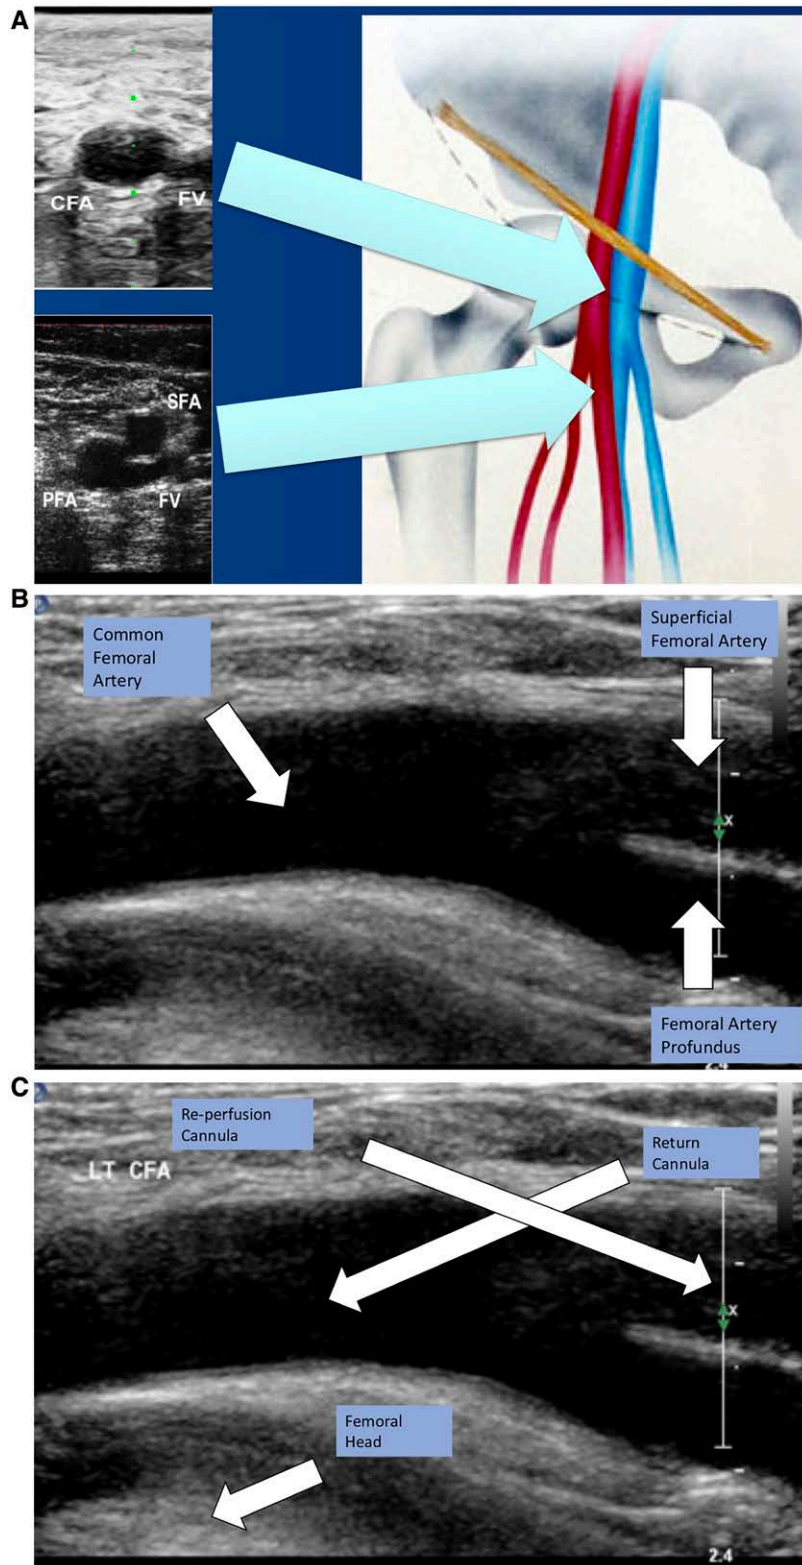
A: Vascular ultrasound in short axis of demonstrating the relationship of the CFA and CFV, the bifurcation of the SFA and PFA, inguinal ligament and femoral head. Note the FV courses below the superficial femoral artery. B: Longitudinal vascular ultrasound of the CFA as it bifurcates to the superficial femoral artery and the PFA. C: Longitudinal vascular ultrasound of the femoral artery demonstrating the relationship to the femoral head and the needle entry position of the arterial return cannula and the distal perfusion catheter (By courtesy of Dr. Wallace Ngai, Hong Kong). CFA, common femoral artery; CFV, common femoral vein; FV, femoral vein; PFA, profound femoral artery; SFA, superficial femoral artery.
